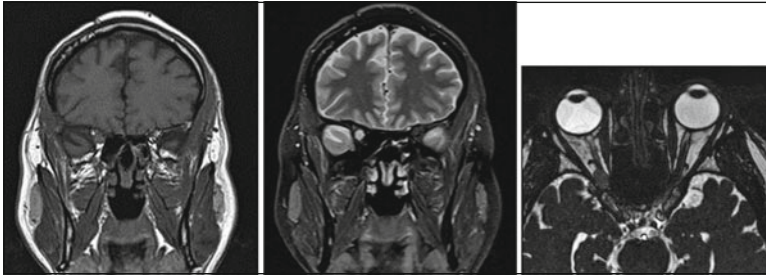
MRI of a patient with an optic nerve sheath meningioma. *Left:* $T1$ -weighted coronal section. *Middle:* $T2$ -weighted coronal section with fat suppression. *Right:*
